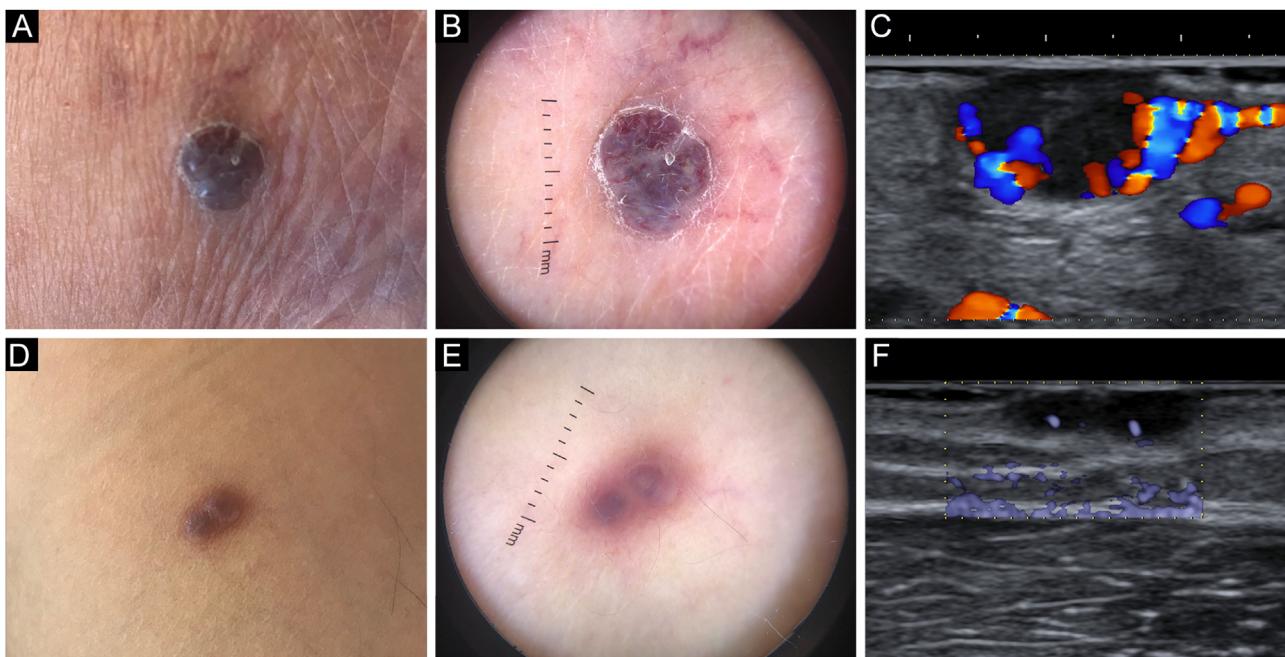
Clinical, dermoscopic (Dermlite DL200 Hybrid handheld device, 3 Gen, San Juan Capistrano, CA) and sonographic (ARIETTA 850 multifrequency 15.0–18.0 MHz linear array transducer, Hitachi Medical Systems®, Zug, Switzerland) appearance of studied lesions from patients 1 (A–C) and 2 (D–F).
